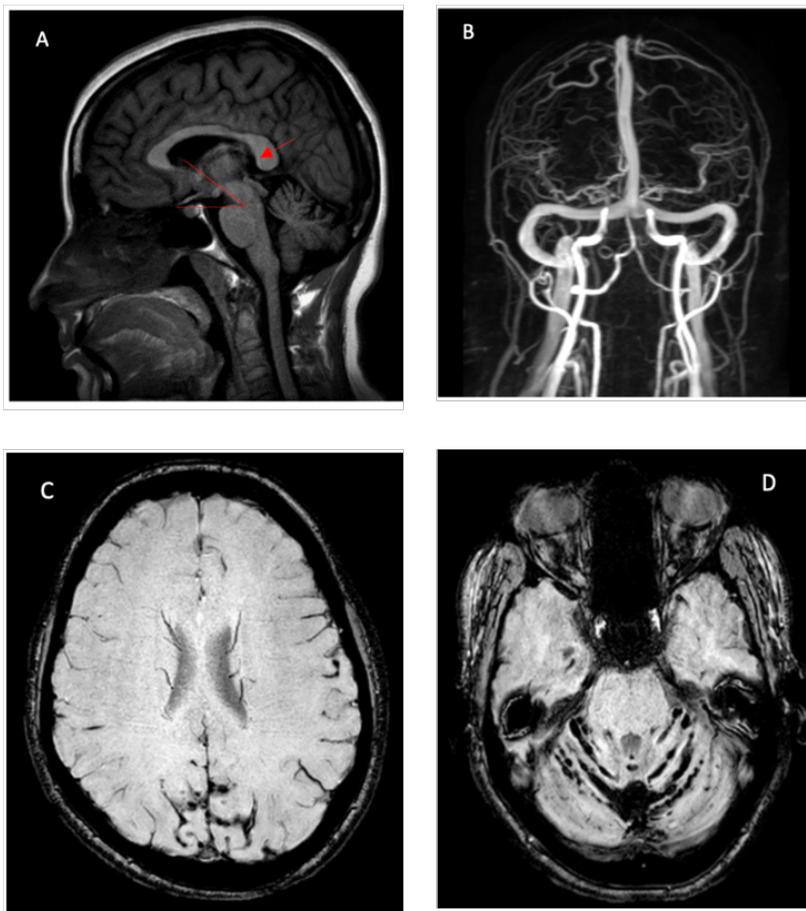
(A) and (B): MRI showing pontomesencephalic angle $< 50^\circ$ and sagging of corpus callosum, (C and D) SWI image showing superficial siderosis
